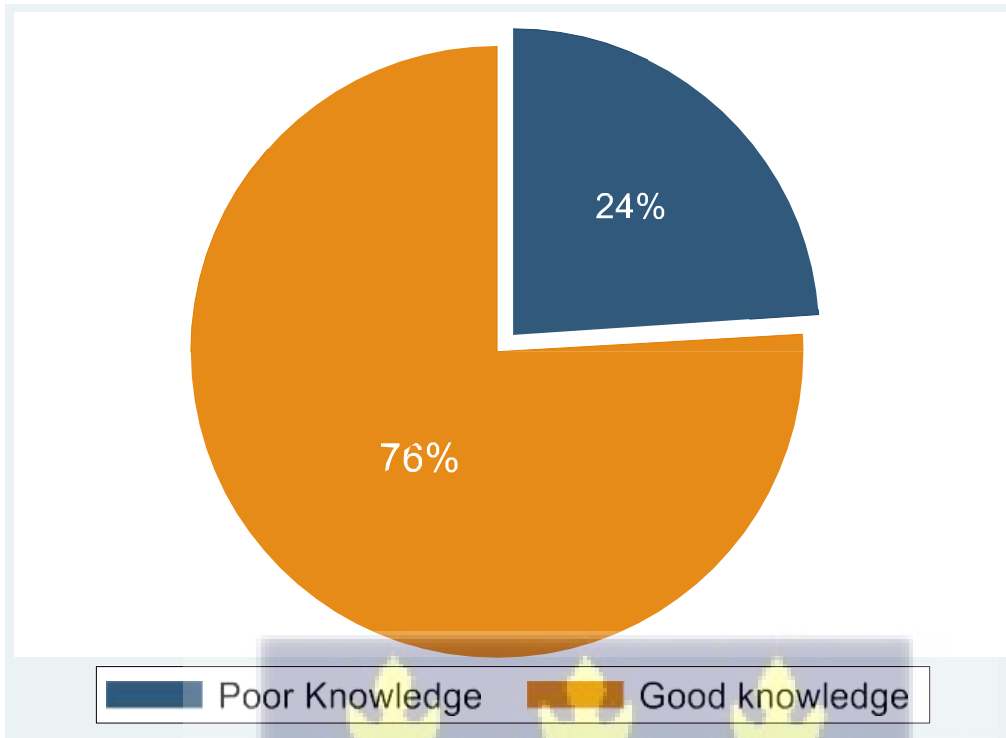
Knowledge of radiographers on ethical standards
